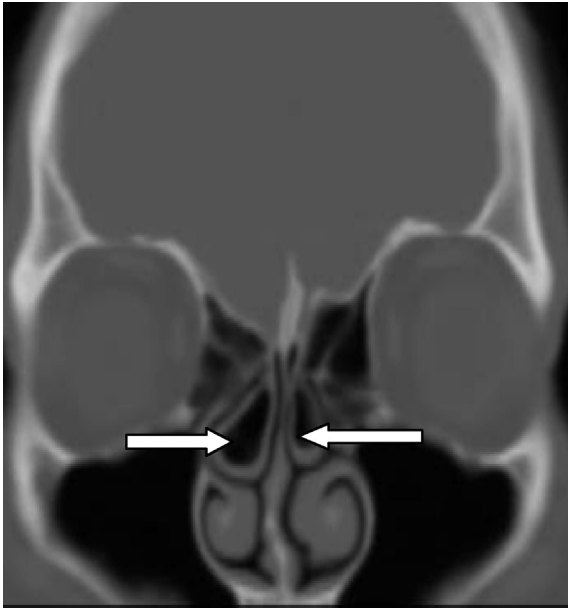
Coronal CT image shows bilateral middle turbinate pneumatization (arrow).
